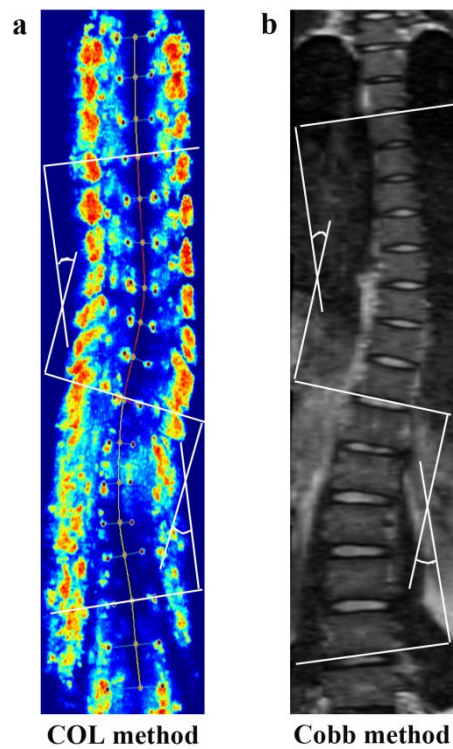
1 Magnetic resonance imaging (MRI) systems for scoliosis assessments
